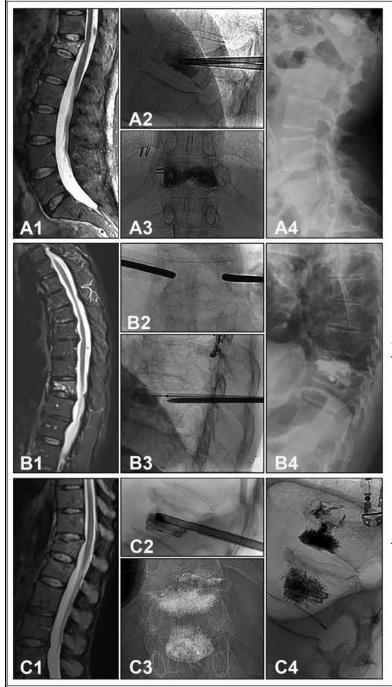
Images of Vertebral Augmentation Procedures. Images (A1-A4) are of patient undergoing vertebroplasty procedure: (A1) Sagittal STIR MRI showing bone marrow edema and vertebral compression fracture at T12; (A2) Procedural lateral fluoroscopic image with vertebroplasty needles in position (A3) Anterior-Posterior fluoroscopic image after needle removal showing bilateral cement distribution; (A4) Lateral radiograph showing vertebroplasty at T12. Note cholecystectomy clips and partially visualized inferior vena cava filter. Images (B1-B4) are of patient undergoing balloon vertebroplasty procedure: (B1) Sagittal Short Tau Inversion Recovery magnetic resonance imaging displaying T10 pathologic fracture; (B2) Anterior-Posterior fluoroscopic image showing transpedicular needle placement; (B3) Lateral fluoroscopic image with balloon inflated (B4) Lateral radiograph with T10 cement and small volume cement extension along pedicle needle tracks. Images (C1-C4) are of patient undergoing Kiva procedure: (C1) Sagittal Short Tau Inversion Recovery magnetic resonance imaging displaying T12 and L1 vertebral compression fracture; (C2) Lateral fluoroscopic image with PEEK Kiva coil partially deployed; (C3) Anterior-Posterior fluoroscopic image showing KIVA and cement at L1 and vertebroplasty cement at T12; (C4) Lateral fluoroscopic image showing vertebroplasty cement at T12 with small volume intradiscal leakage and L1 Kiva implant and cement.
